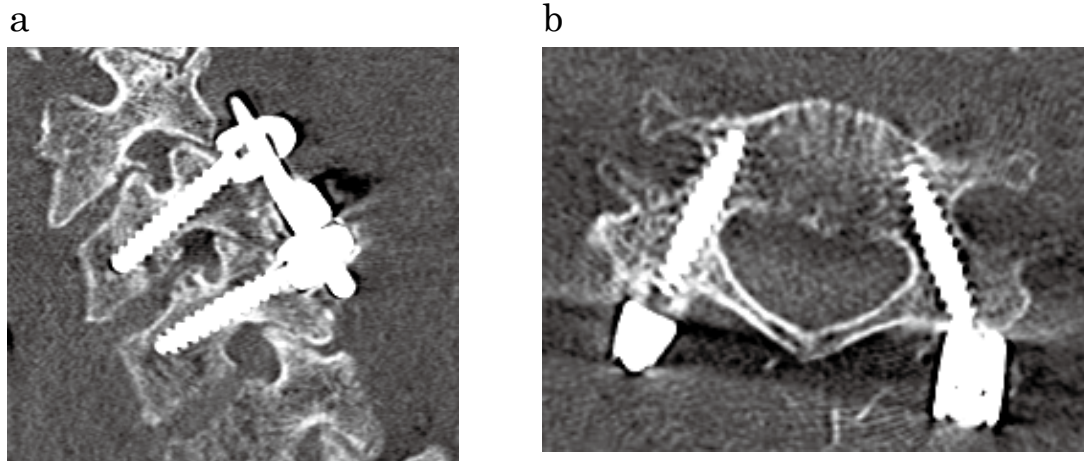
Postoperative computed tomography scans showing pedicle screws completely contained within the pedicle. (a) Sagittal view. (b) Axial view.
